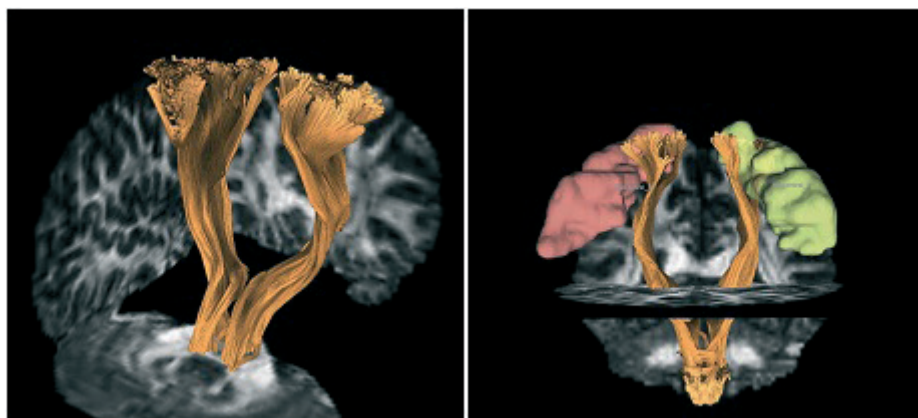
Magnetic resonance imaging image
